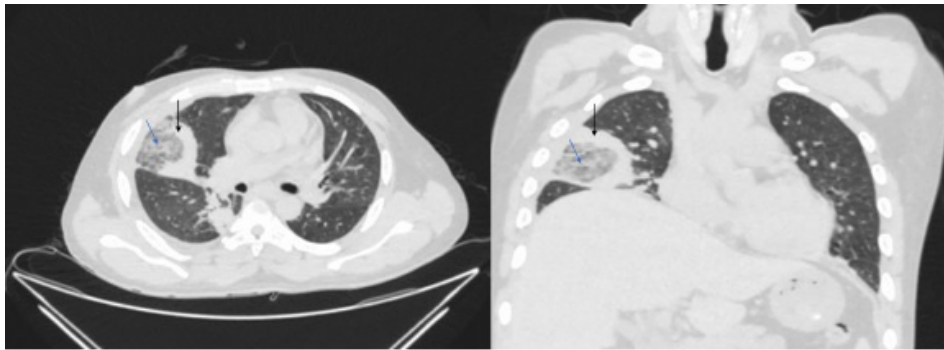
CT thorax showing area of consolidation (black arrows) with areas of internal ground glass densities within (blue arrows) i.e. “reversed halo” sign
